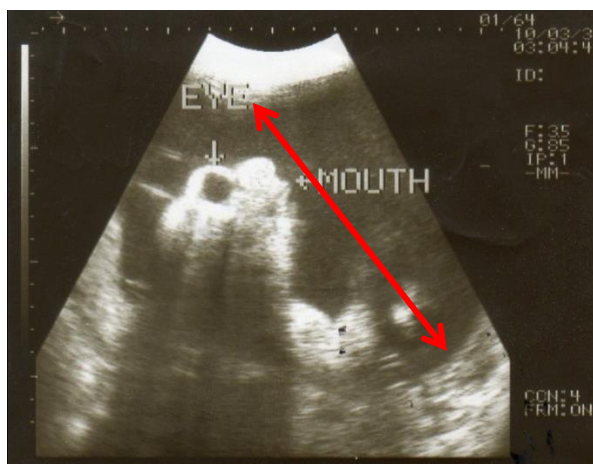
Coronal ultrasound shows frog eye appearance.
